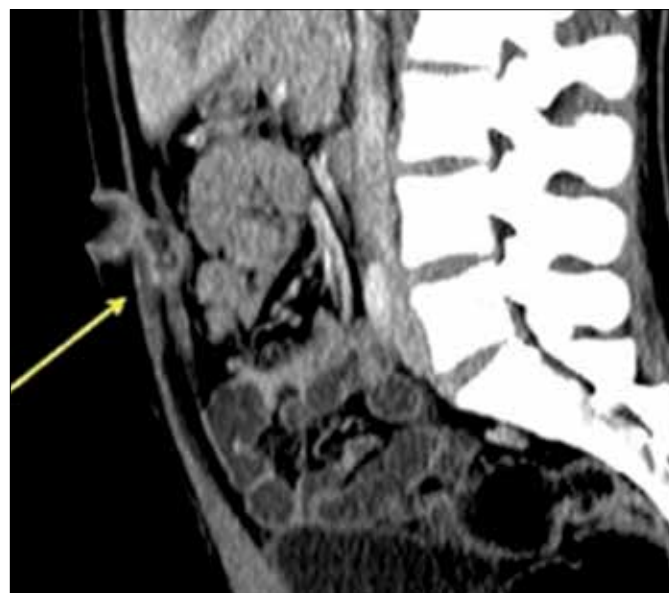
The midline cyst shown at CT.
